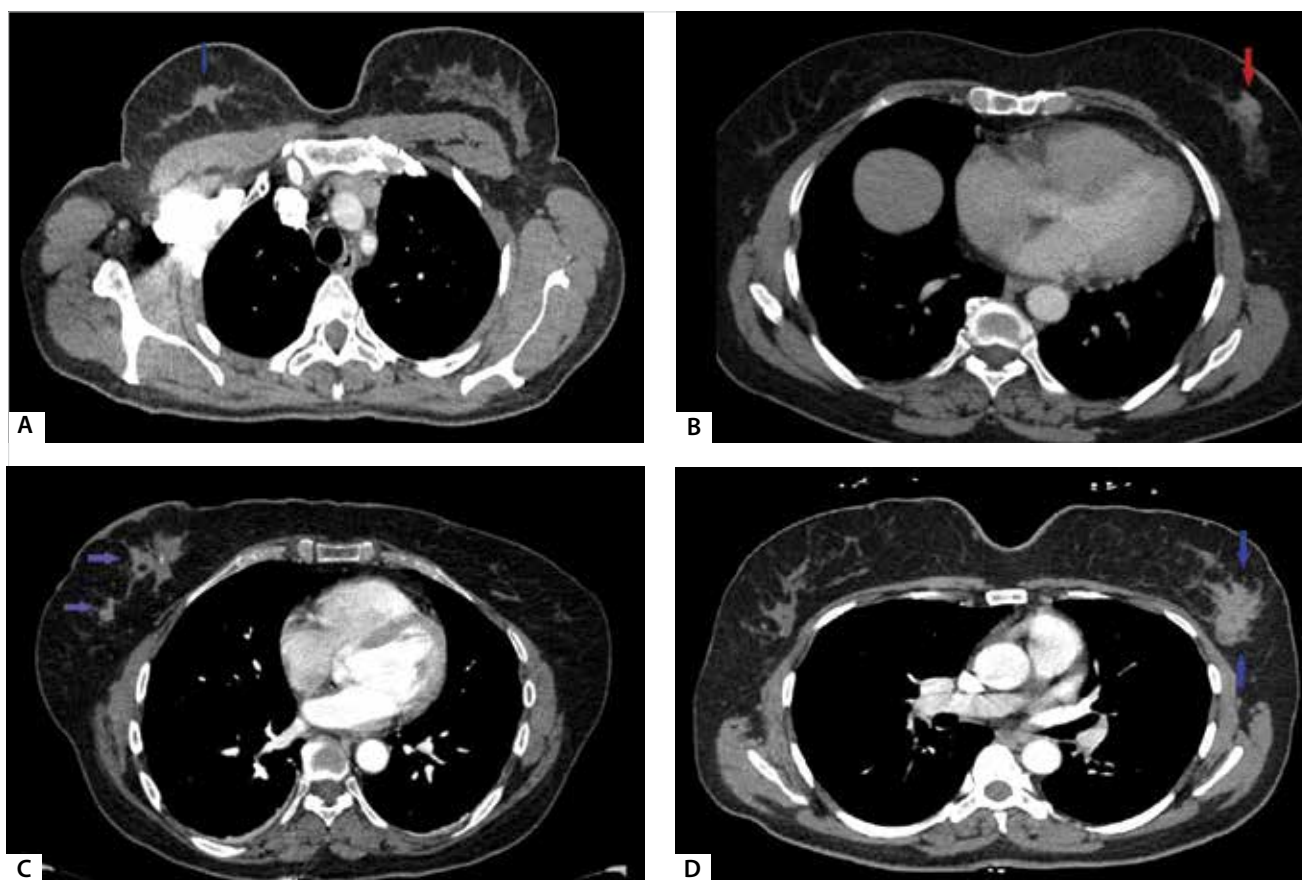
Axial CT image is shown (A) a speculated lesion (blue arrow) with moderate enhancement in the upper middle quadrant of right breast with moderate malignancy suspicion ratio ($x=10-50\%$, BI-RADS 3), (B) well defined mass appearance (red arrow) with homogeneous enhancement in the upper middle quadrant of left breast with moderate malignancy suspicion ratio ($x=50-90\%$, BI-RADS 4), (C) two speculated neighboring lesions (purple arrows) with calcifications in the lower inner quadrant of right breast with high malignancy suspicion ratio ($x > 95\%$: BI-RADS 5) and increased skin thickness was also demonstrated in the image, (D) a well-defined, speculated countered mass appearance (blue arrows) with high enhancement pattern in the upper outer quadrant of left breast. This lesion reflects a high-grade malignancy suspicion ratio ($x > 95\%$: BI-RADS 5).
